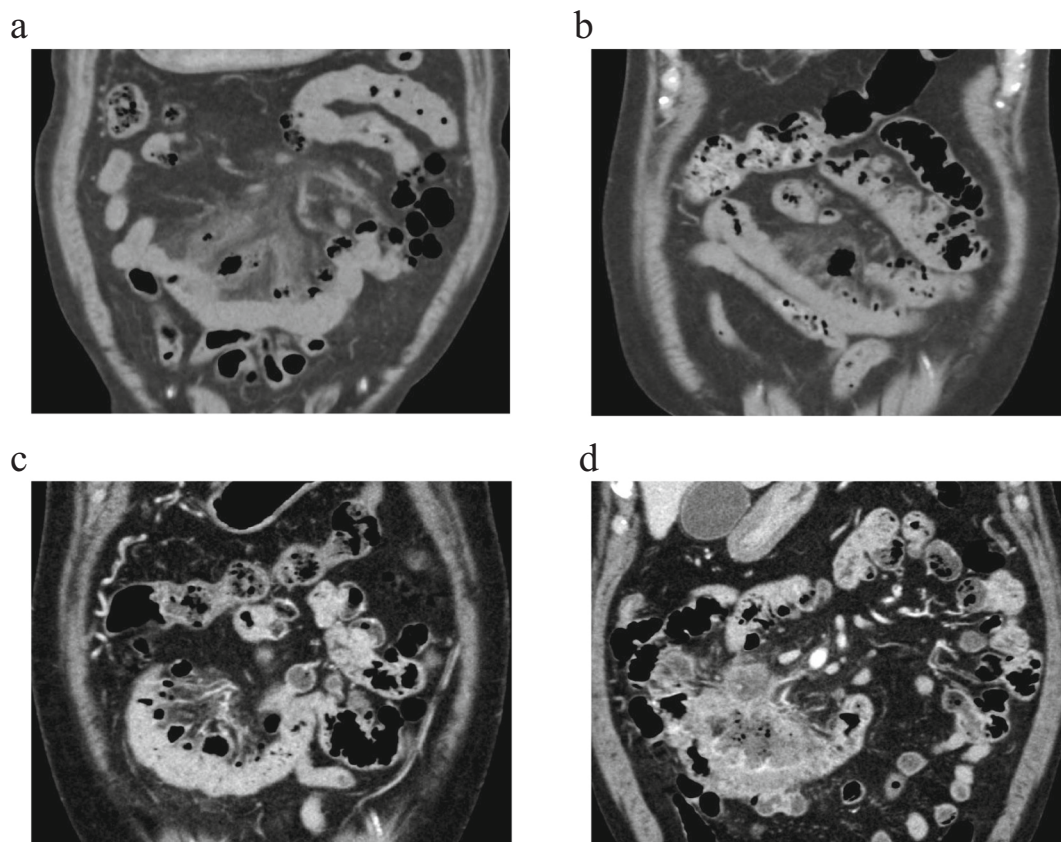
Preoperative computed tomography images.
